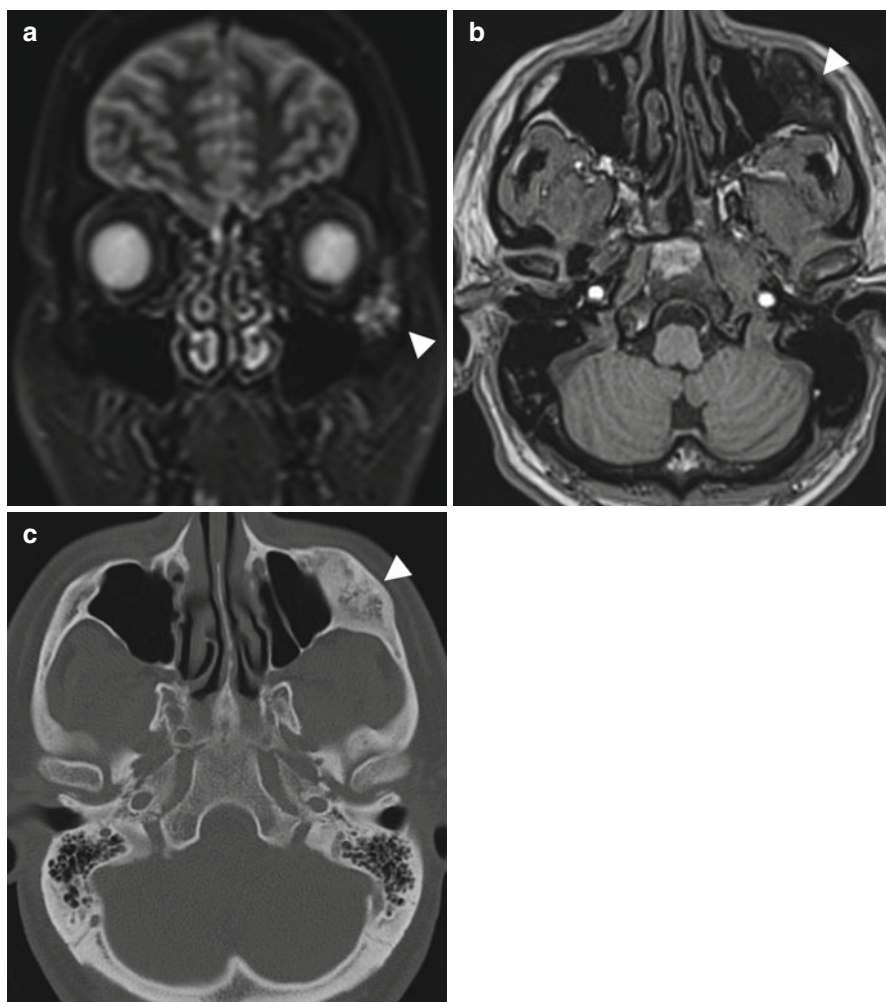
Incidental screening finding (STIR) and diagnostic workup. Thirty-five-year-old male subject with an expansive mass of the left zygomatic arch (*arrowhead*). The mass has high signal intensity on STIR image (a) and low signal intensity on axial T1w TSE image (b). Diagnostic workup with CT demonstrates the characteristic appearance of fibrous dysplasia with incomplete mineralization of the fibrous matrix (c)
